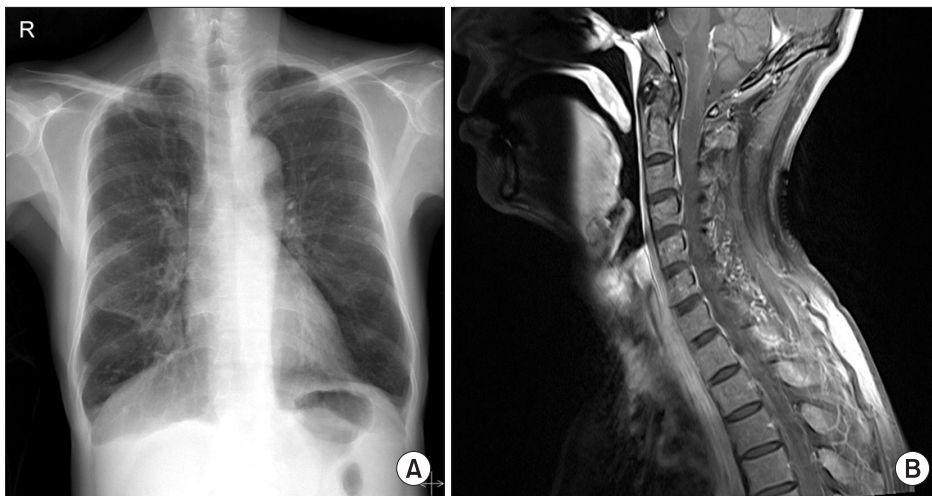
Follow-up of chest X-ray and cervical spine magnetic resonance. (A) Decreased ground glass opacity and consolidation on both lung fields were noted. (B) There is no abnormal signal nor contrast enhancement in C-spine and leptomeninges.
